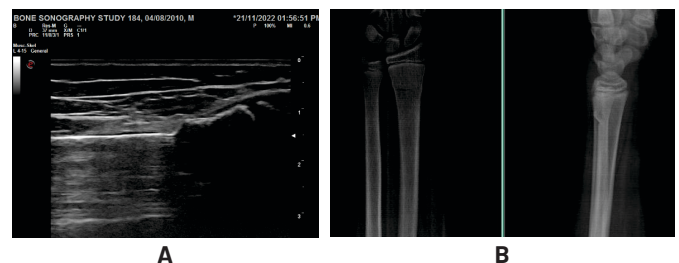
(A) cortical buckling, (B) X-Ray of the same patient
